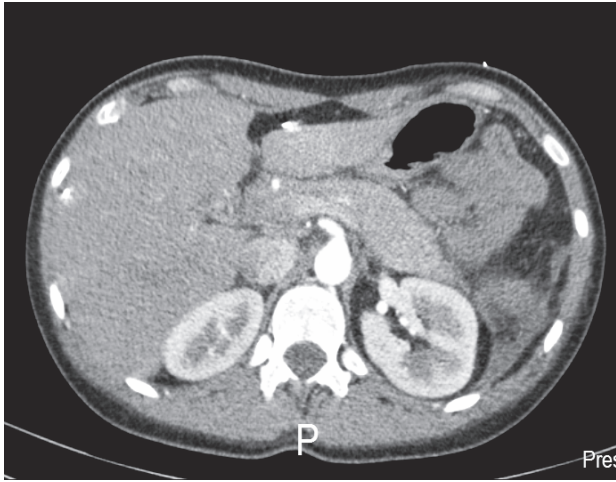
Postoperative abdominal computed tomography image showing moderate oedema of the head of the pancreas and a small fluid collection near the tail of the pancreas.
